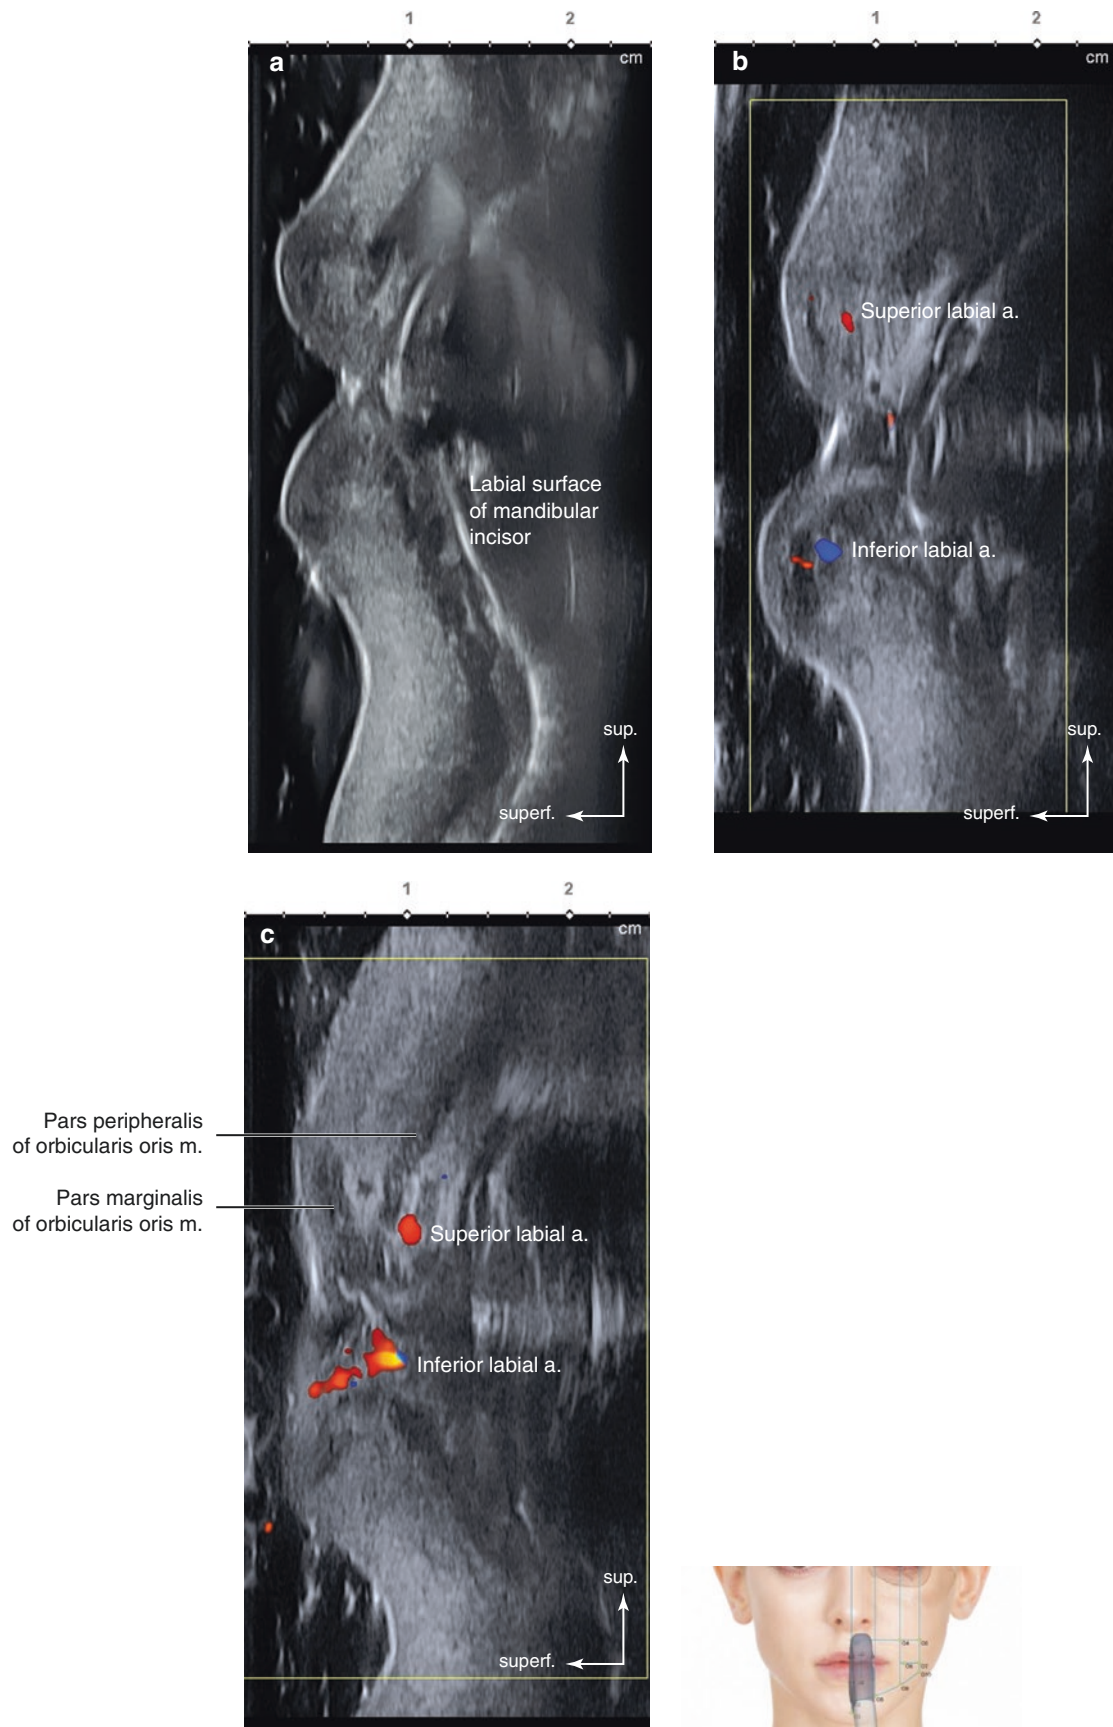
Ultrasonography on the perpendicular line between Ls2 and Li2 (Ls2–Li2). (a) B mode (sagittal view, 15 MHz by linear transducer), (b) Doppler mode (sagittal view, 15 MHz by linear transducer), and (c) Doppler mode (sagittal view, 15 MHz by linear transducer). (Published with kind permission of © Hee-Jin Kim 2020. All Rights Reserved)
